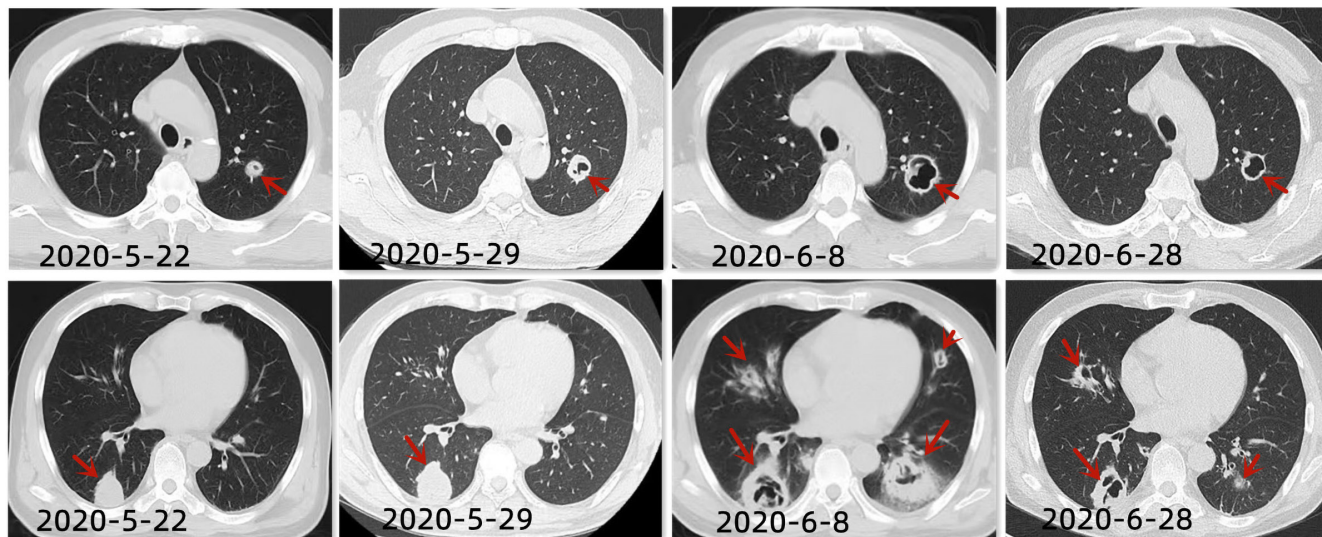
Chest CT showed multiple pulmonary nodules and cavities, after glucocorticoid treatment, the lesion was significantly reduced.
